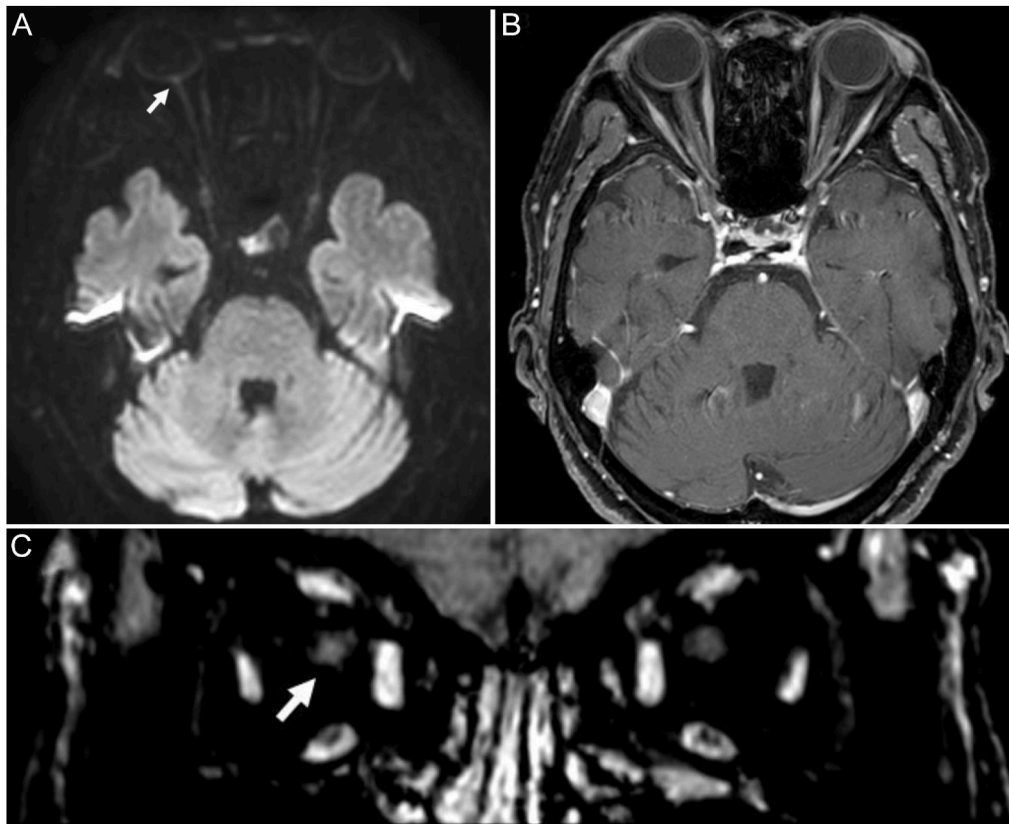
Magnetic resonance imaging (MRI) revealed discoid elevation and restricted diffusion in the right optic nerve head on the diffusion-weighted image (A). There was no significant signal change in the axial fat-suppressed T1-weighted image (B); however, the coronal multiplanar reconstruction image showed a subtle enhancement in the right optic nerve (C).
